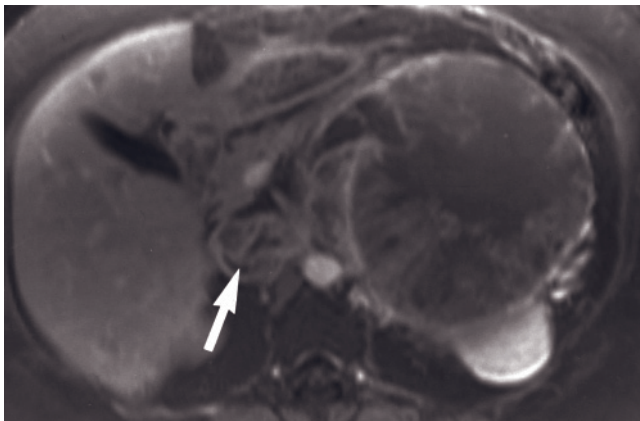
Adrenal cortical carcinoma. Coronal T2-weighted echo-train spin-echo (a), T1-weighted out-of-phase GE (b), immediate postgadolinium GE (c), and 90-s postgadolinium fat-suppressed GE (d, e) images. The large left adrenal cortical carcinoma is heterogeneous on T2 (a). After contrast administration, irregular ring enhancement with a prominent nodular morphology is
